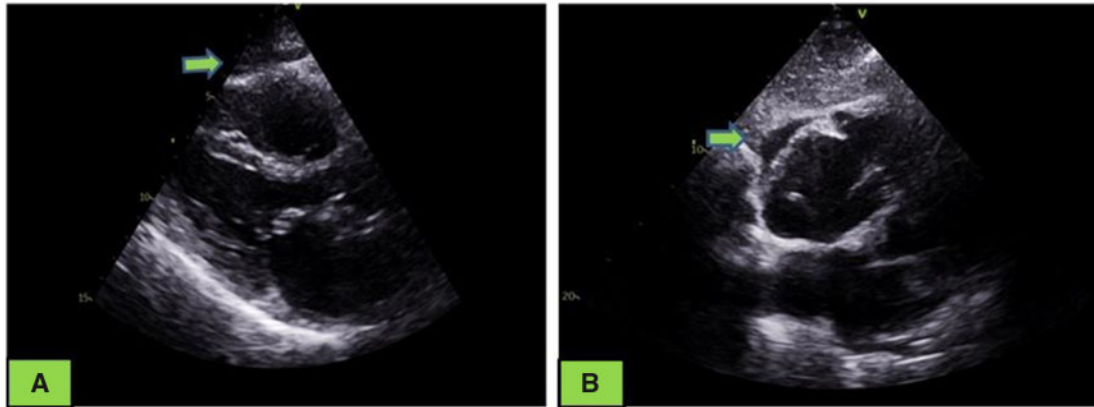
Parasternal long axis (A) and subcostal view (B) shows small global pericardial effusion without tamponade.
